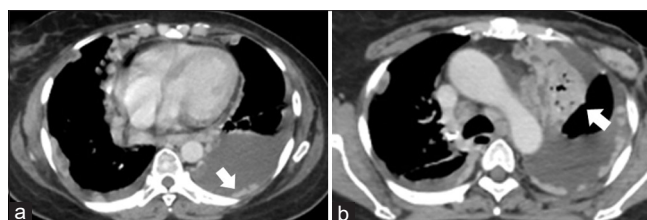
Contrast enhanced computed tomography image of thorax showing mild right pleural effusion and moderate left-sided pleural effusion with multiple bilateral pleural deposits (arrow in a). There is collapse of the left lung upper lobe (arrow in b)
